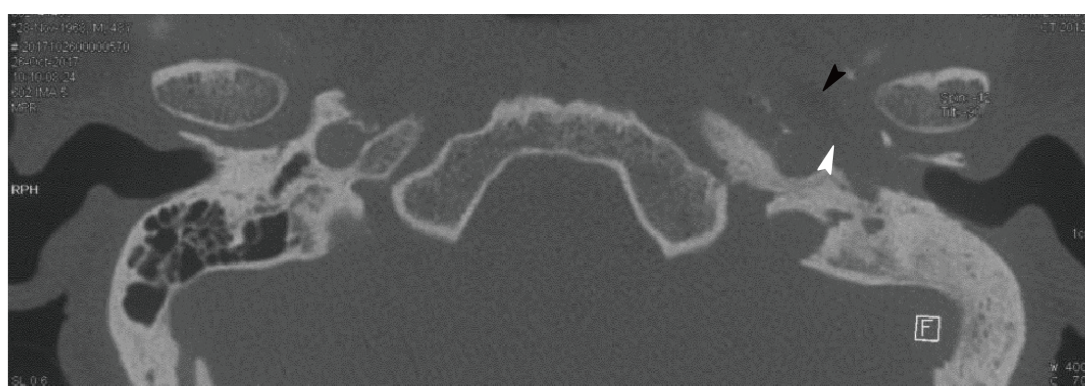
High-resolution computed tomography scan of the patient's temporal bone. Computed tomographic imaging showed a well-circumscribed, mixed density tumor (white arrowhead) with a fat density area (black arrowhead) located in the eustachian tube.
